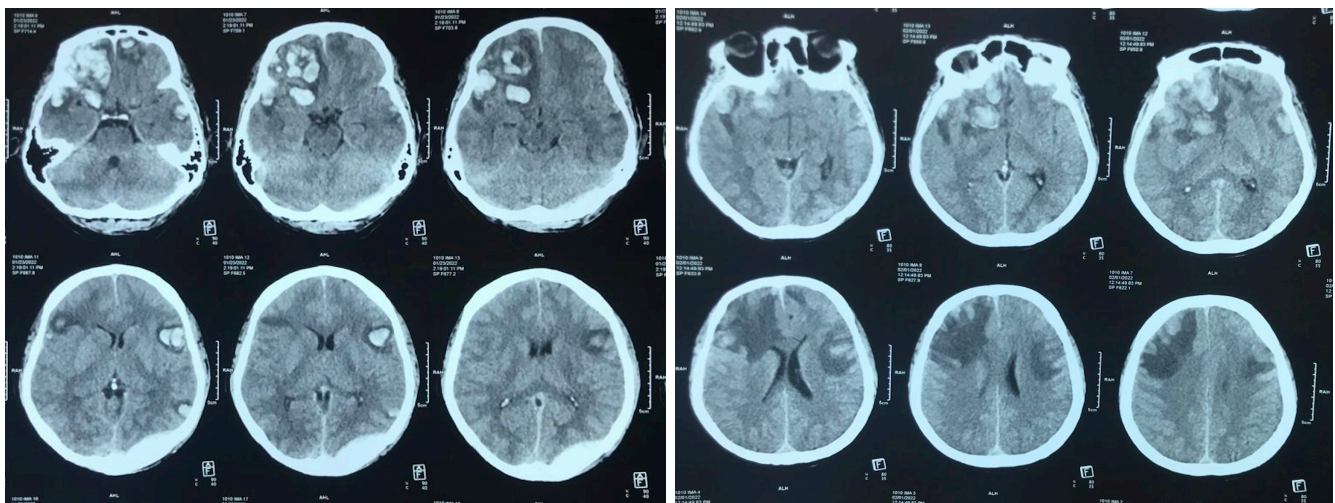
Resolution of cerebral hematoma on repeat CT head
